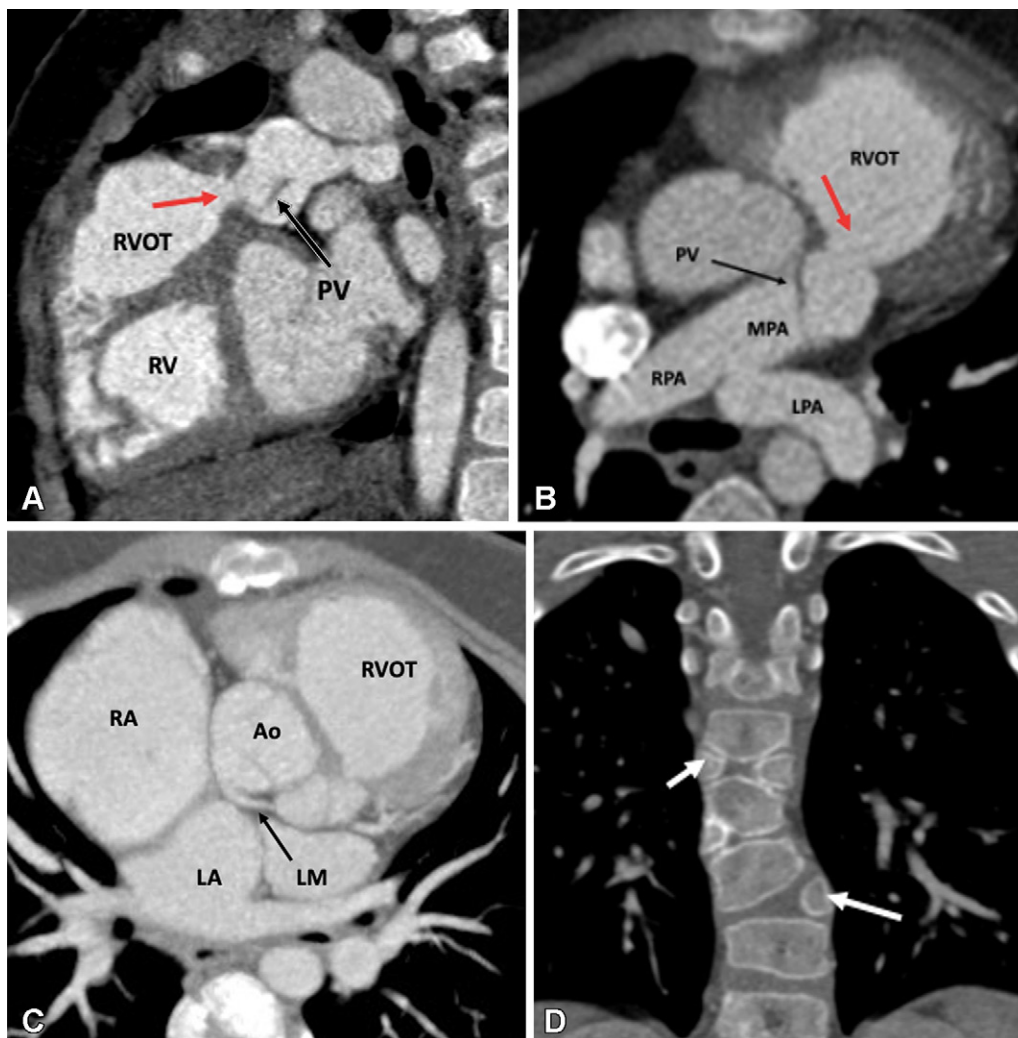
Postoperative appearance of TOF-type DORV after VSD closure with LV routing, infundibular resection, and patch augmentation of the RVOT up to the main pulmonary artery in a 4-month-old male infant. (A) Sagittal oblique and (B) axial multiplanar reconstruction CT images show dilated RV and RVOT. There is residual subvalvular narrowing (red arrow). The residual pulmonary valve tissue is shown with a black arrow. The MPA, RPA, and LPA appear normal. (C) Axial maximum intensity projection (MIP) CT image shows anomalous origin of the left main coronary artery (black arrow) from the noncoronary sinus with retroaortic course. (D) Coronal reformatted MIP CT image shows multiple hemivertebrae (white arrows). Ao = aorta, DORV = double-outlet right ventricle, LA = left atrium, LM = left main, LPA = left pulmonary artery, LV = left ventricle, MPA = main pulmonary artery, PV = pulmonary valve, RA = right atrium, RPA = right pulmonary artery, RV = right ventricle, RVOT = right ventricular outflow tract, TOF = tetralogy of Fallot, VSD = ventricular septal defect.
